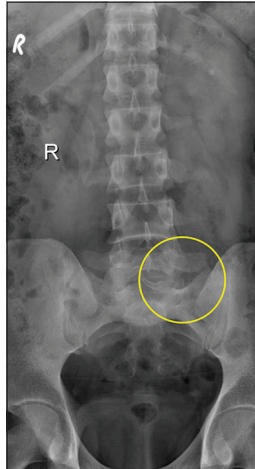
Anteroposterior X-ray image showing the absence of the left L5–S1 zygapophyseal joint.
